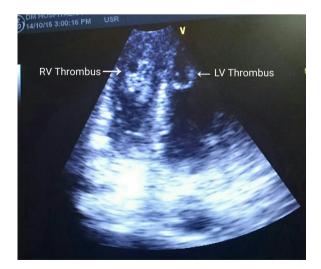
Two-dimensional transthoracic echocardiographic apical four-chamber view showing biventricular thrombi.
